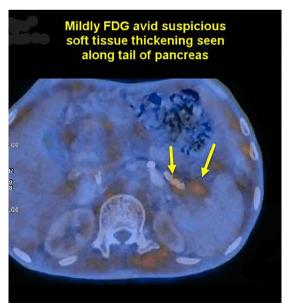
FDG-avid (SUV $_{\rm max}$ 3.6) suspicious soft tissue thickening measuring 16x13 mm was identified along the pancreatic tail
